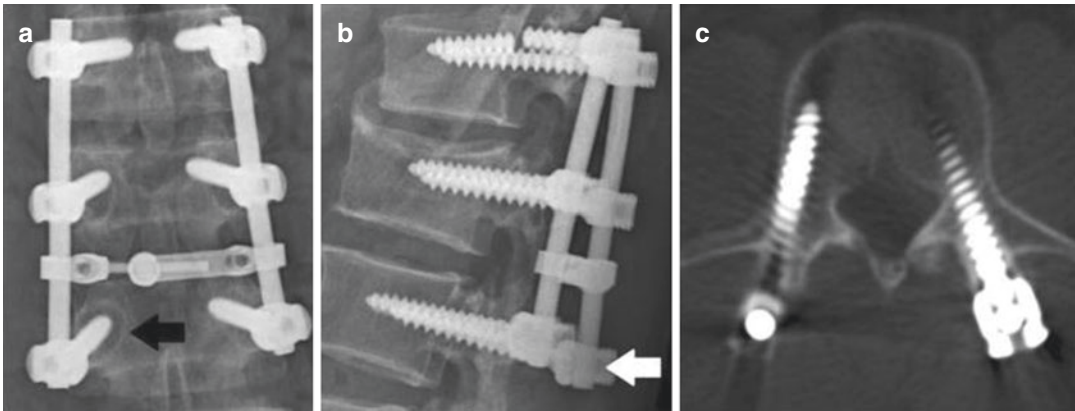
Lumbar radiographs showing (a) anteroposterior X-ray with radiolucent zone and double halo around the screw (black arrow) indicating screw loosening. In addition, there is screw breakage demonstrated at the superior-most level. (b) Lateral X-ray demonstrating that
